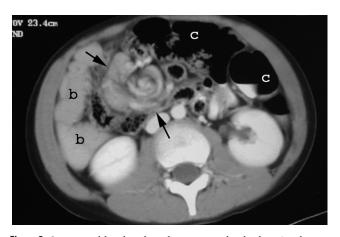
Six-year-old girl with malrotation and volvulus. Axial computed tomography image shows small bowel and vasculature has a whirled appearance in the right mid-abdomen (arrows), consistent with volvulus. Small bowel (b) is at right and colon (c) is at left. At surgery, no ischemia was evident.
